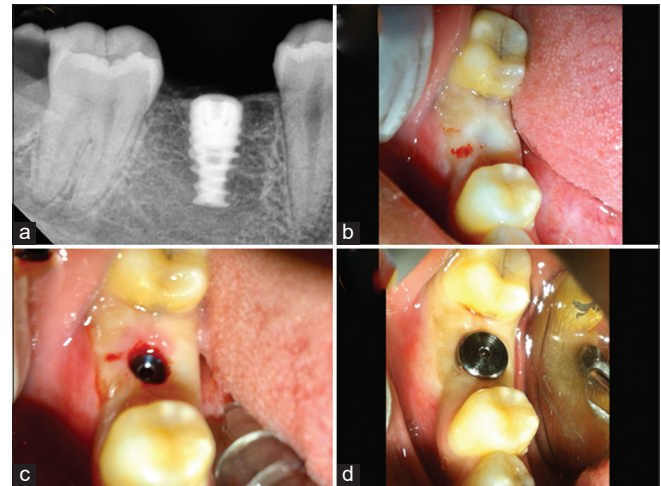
Second-stage surgery (a) intraoral periapical after 3 months of healing, (b) after local anesthesia, (c) implant exposure using tissue punch, (d) healing screw placement
